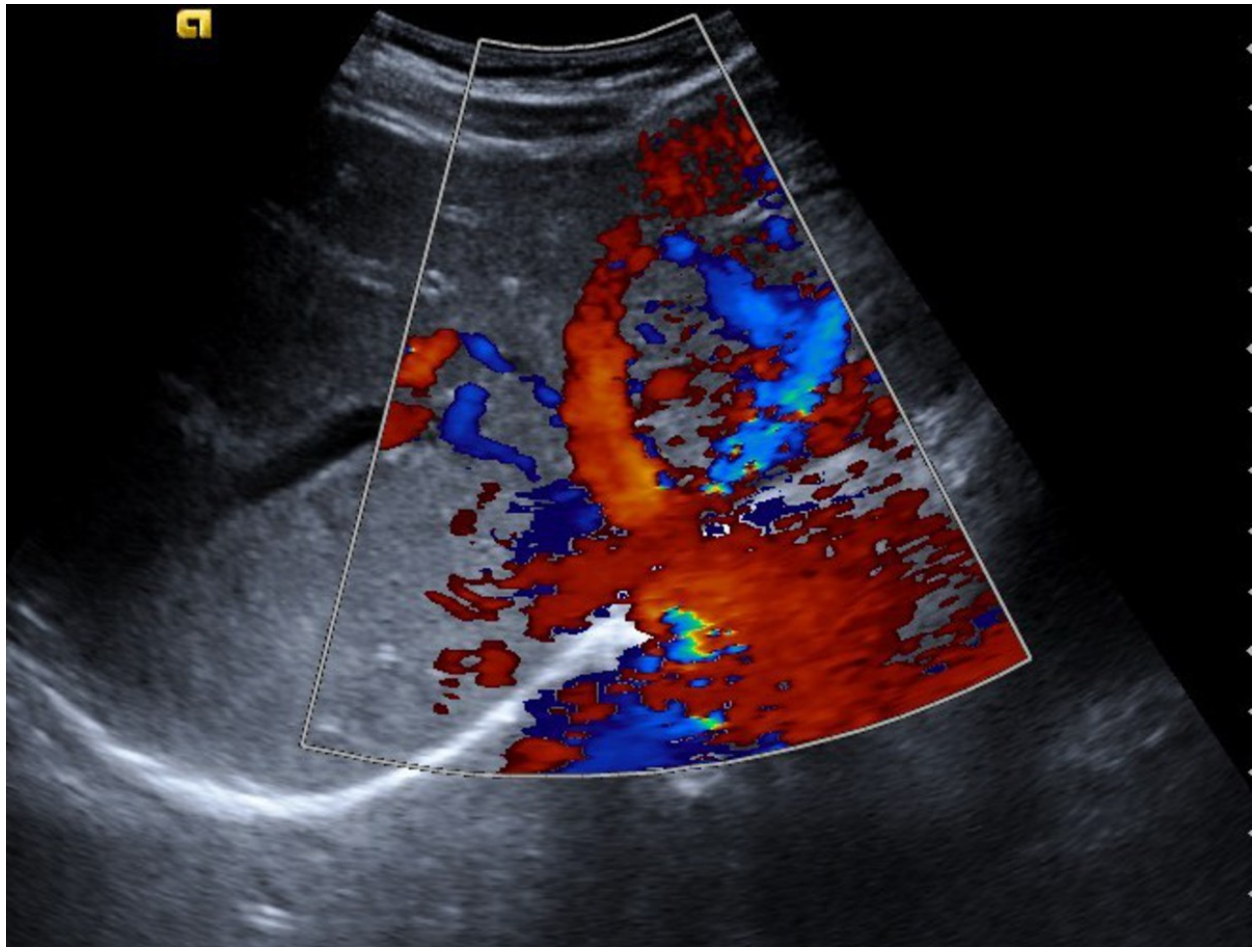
Color Doppler ultrasound showing a pattern of bicolored hepatic veins (two adjoining hepatic veins with flow in opposite directions on color Doppler sonography).
